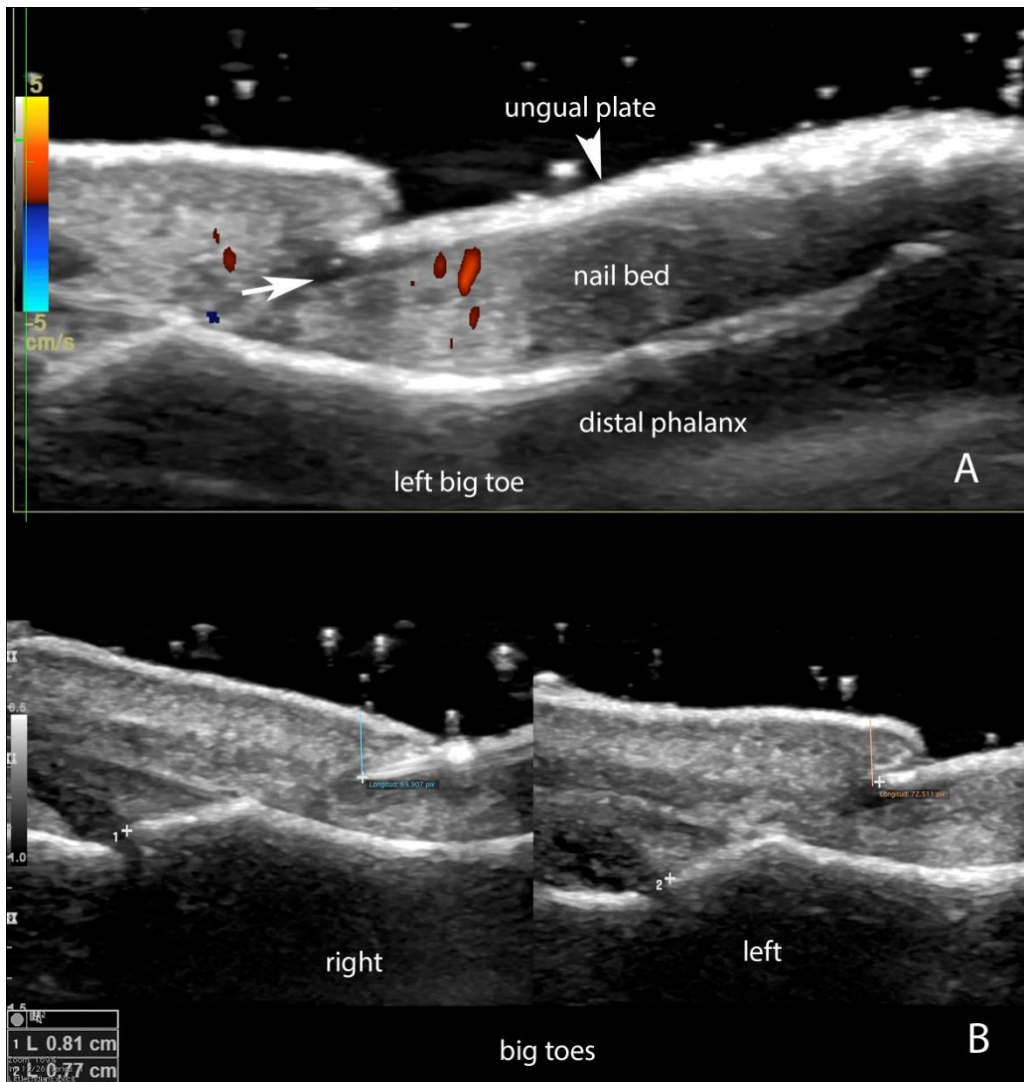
(A, B). Color Doppler ultrasound of retronychia without onychomadesis at the left big toe. (A, longitudinal view; left big toe; B, side-by-side comparison of the big toes; longitudinal views). A. Thickening and slight increase of the vascularity at the proximal part of the nail bed and nail fold. Thickening of the nail plate with loss of the bilaminar pattern. Notice the hypoechoic tissue surrounding the origin of the unguis plate (arrow pointing right). B. Decreased distance between the origin of the nail plate and the base of the distal phalanx at the left big toe (7.7 mm left versus 8.1 mm right)
